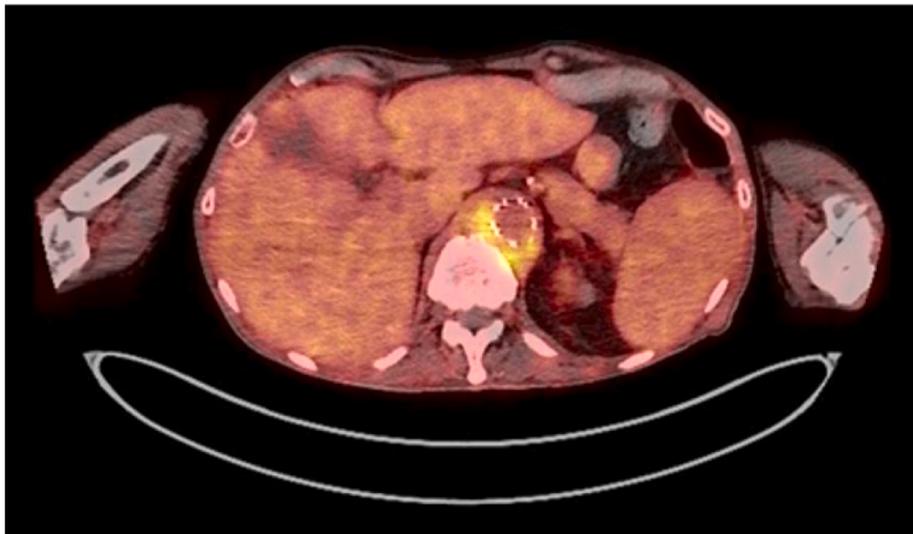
Axial section of CT-PET demonstrating multifocal, non-circumferential intense metabolic foci at thoracic stent-aneurysm interface in keeping with mycotic infection.
